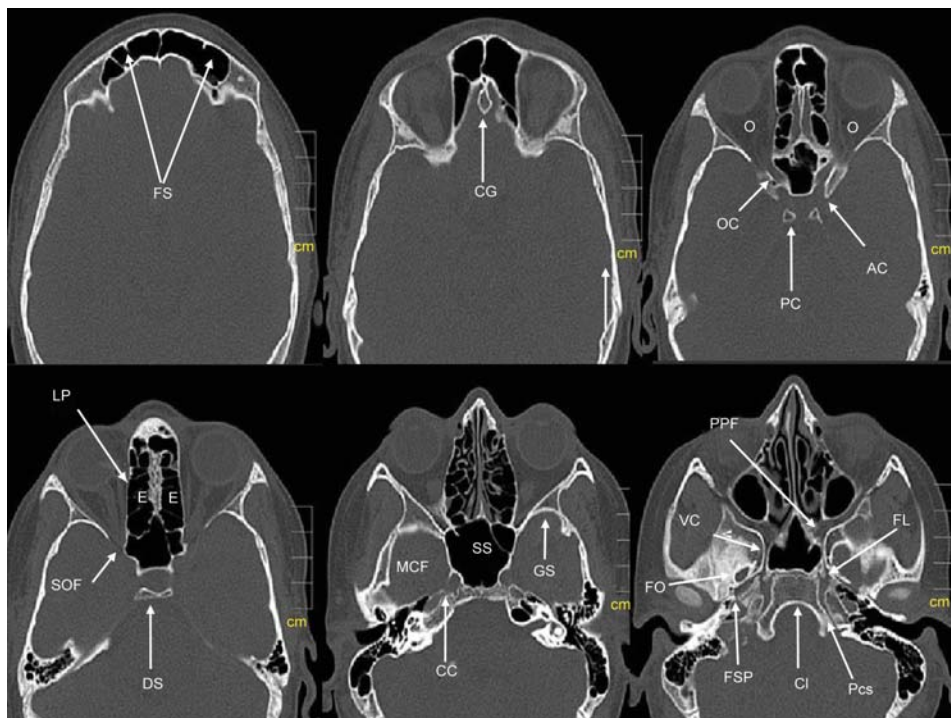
Axial CT bone window, FS: Frontal sinus; CG: Crista galli; OC: Optic canal; AC: Anterior clinoid process; PC: Posterior clinoid process; O: Orbit; LP: Lamina paparacea; E: Ethmoid air cells; DS: Dorsum sellae; SOF: Superior orbital fissure; SS: Sphenoid sinus; GS: Greater wing of sphenoid; MCF: Middle cranial fossa; CC: Carotid canal; FO: Forane ovale; FSP: Foramen spinosum; VC: Vidian canal; FL: Foramen lacerum; PCS: Petroclival suture; Cl: Clivus; PPF: Pterygopalatine fossa
